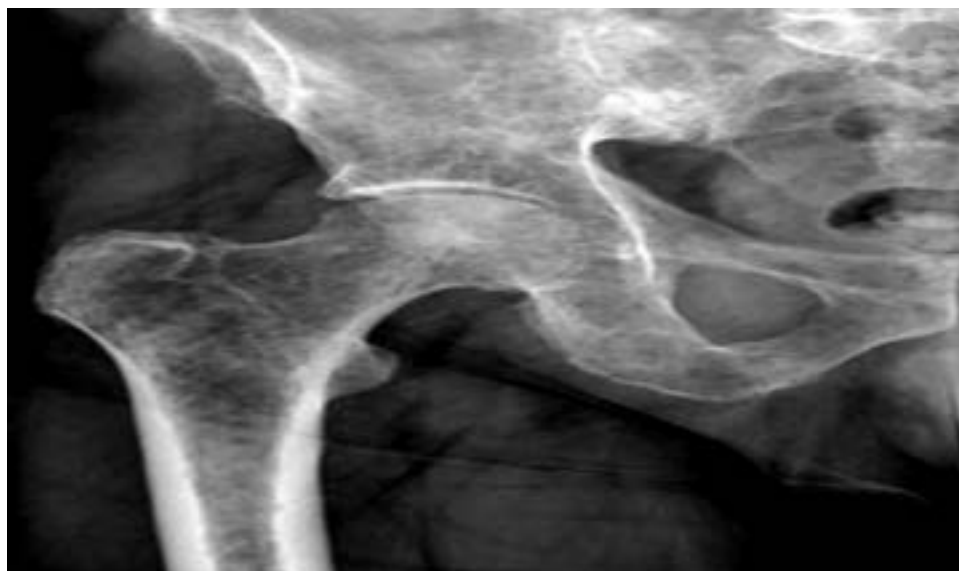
Plain X-ray image of right hip joint showed osteoporosis inside the head of femoral bone.
